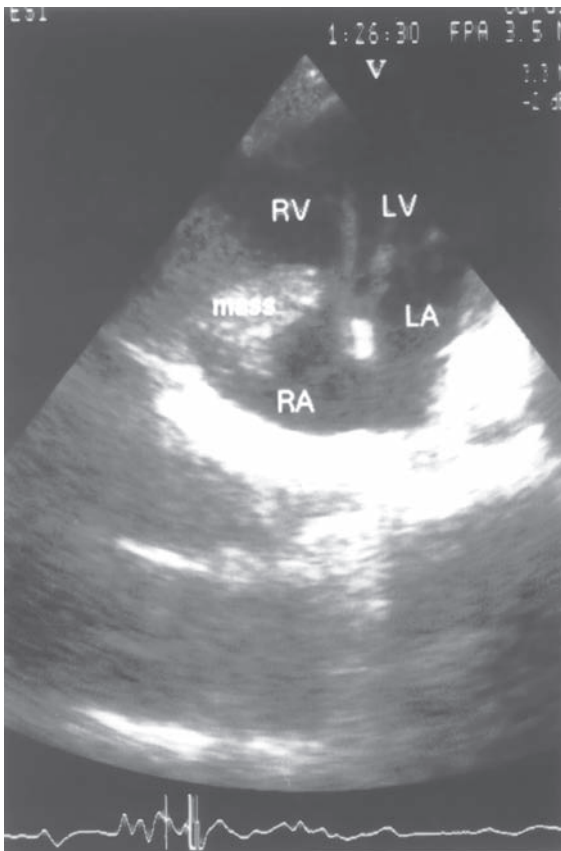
Echocardiographic appearance of the intra-atrial mass.
